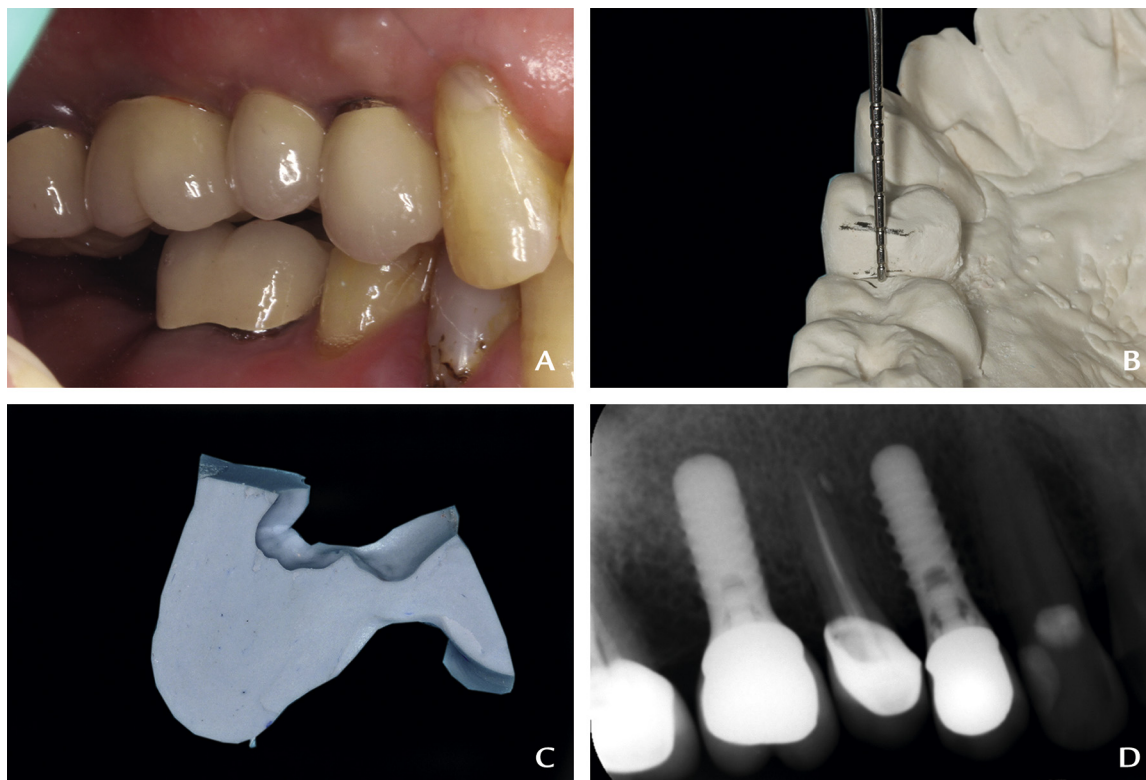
Intrusion of maxillary right second premolar 4 months after prosthesis placement. A, Buccal view. B, 3-mm intrusion indicated on stone cast. C, Cross-section of silicone occlusal registration also shows 3-mm interocclusal space between maxillary right second premolar and mandibular antagonist. D, Periapical radiograph.
